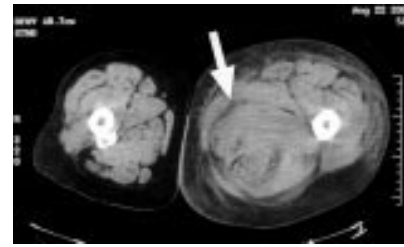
Computed tomogram showing grossly enlarged left thigh.
